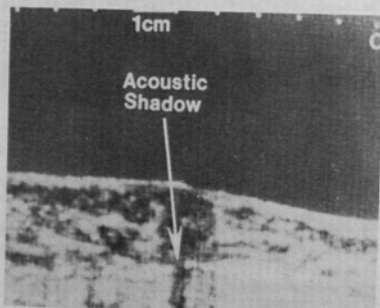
A,B,C: Ultrasound images obtained by scanning a palpable mass in the breast of a 60-year-old patient. Initial transverse scans at 5mm intervals indicate tumor imaging characteristics consistent with a fibroadenoma (A). Longitudinal scans at 1mm intervals (B) and (C) exhibit characteristics of malignancy, namely, jagged walls and central acoustic shadowing.
